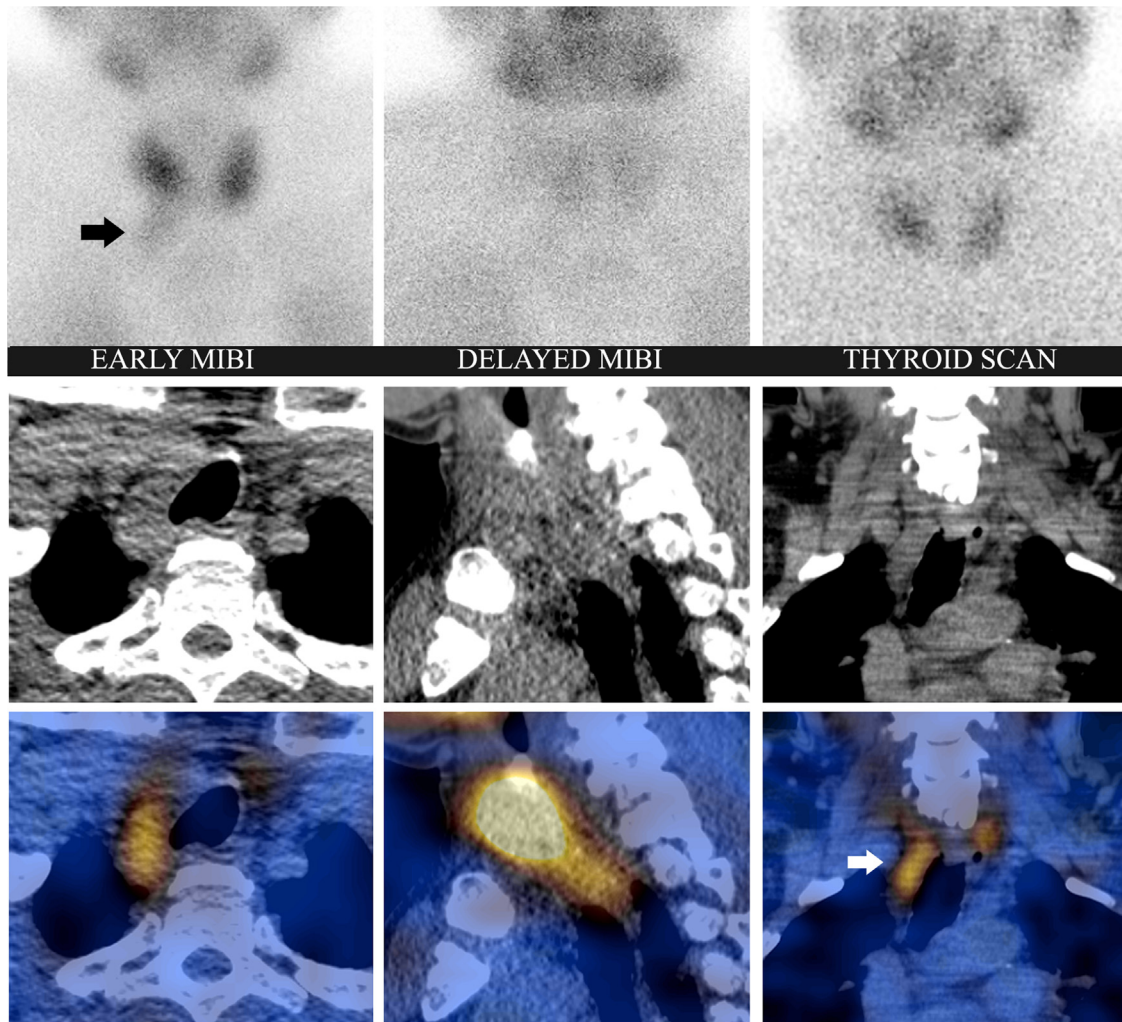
False-positive uptake in the mediastinal vessel: Dual-phase ^{99m}Tc -sestamibi scintigraphy showed low-grade tracer uptake inferior to the right thyroid lobe on the early image, which is not coinciding to the thyroid scan and hence suspicious for a parathyroid adenoma. However, SPECT/CT localizes this abnormal tracer uptake to the mediastinal vessel.
